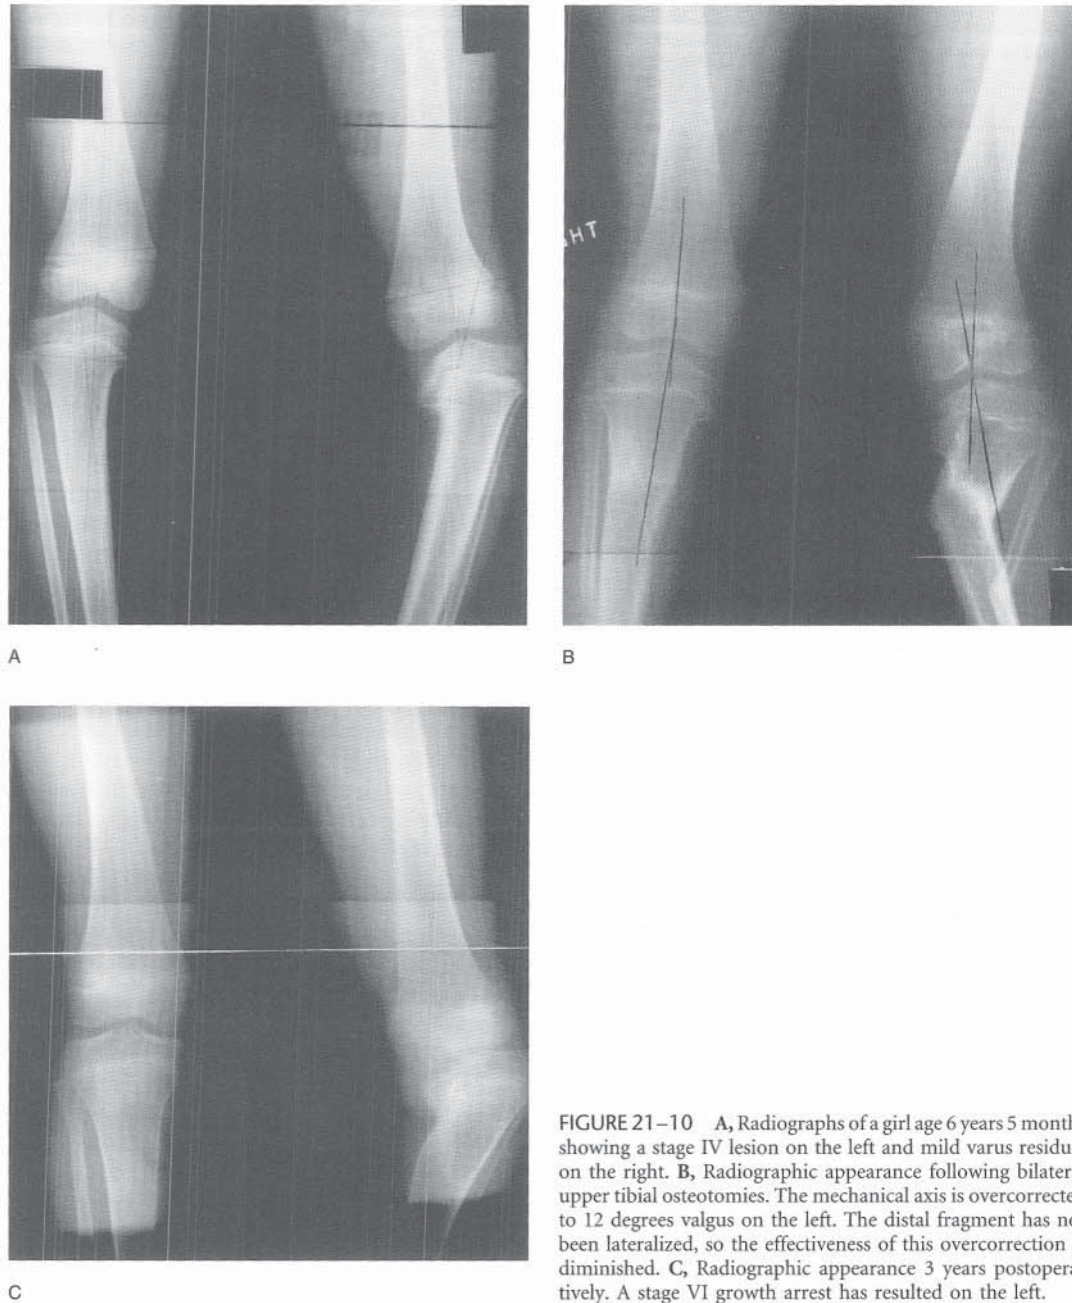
A, Radiographs of a girl age 6 years 5 months showing a stage IV lesion on the left and mild varus residual on the right. B, Radiographic appearance following bilateral upper tibial osteotomies. The mechanical axis is overcorrected to 12 degrees valgus on the left. The distal fragment has not been lateralized, so the effectiveness of this overcorrection is diminished. C, Radiographic appearance 3 years postoperatively. A stage VI growth arrest has resulted on the left.
